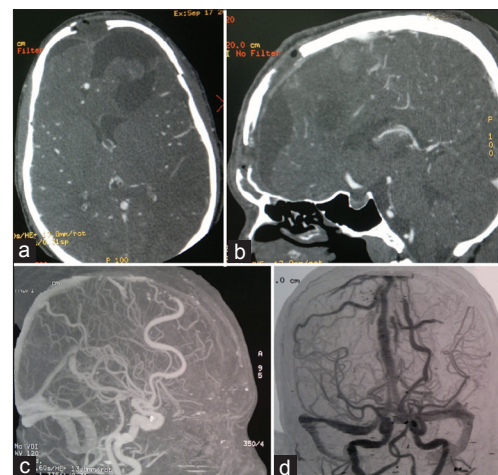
Postoperative contrast enhancing cerebral computed tomographic axial (a) and sagittal, (b) picture demonstrates a large filling defect in the area of the varix excision. Computed tomographic angiography (c and d) shows complete obliteration of the arteriovenous fistulas and reconstitution of the distal anterior cerebral artery
